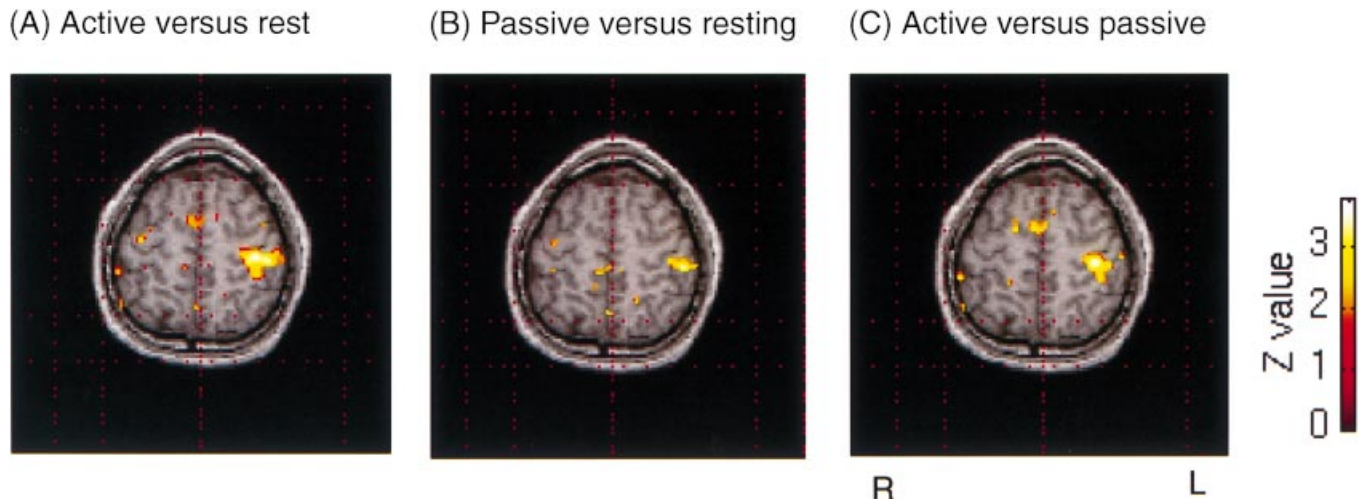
Comparison of rCBF activation in the active and passive movement of the right middle finger, and the resting condition in a normal subject coregistered with his own MRI. The slices including the hand primary sensorimotor cortex are displayed. The SMA and the left SI are activated by the active movement compared with the resting condition (A) as well as with the passive movement (C). In the passive movement compared with the resting condition (B), only SI is activated at this slice level.
